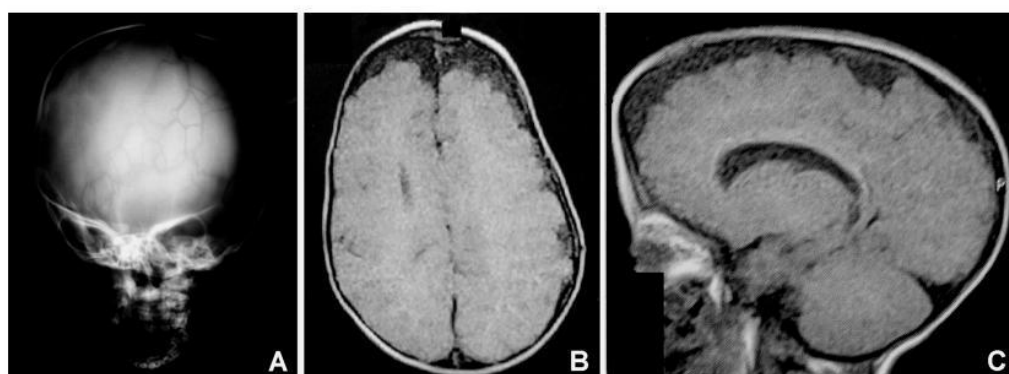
Skull radiograph revealing macrocrania with anteroposterior diameter accentuation (A). Magnetic resonance imaging of the head showed subarachnoid cisterns, enlarged telencephalic grooves, mainly in the frontal lobes, in addition to moderate triventricular dilatation (B and C).
